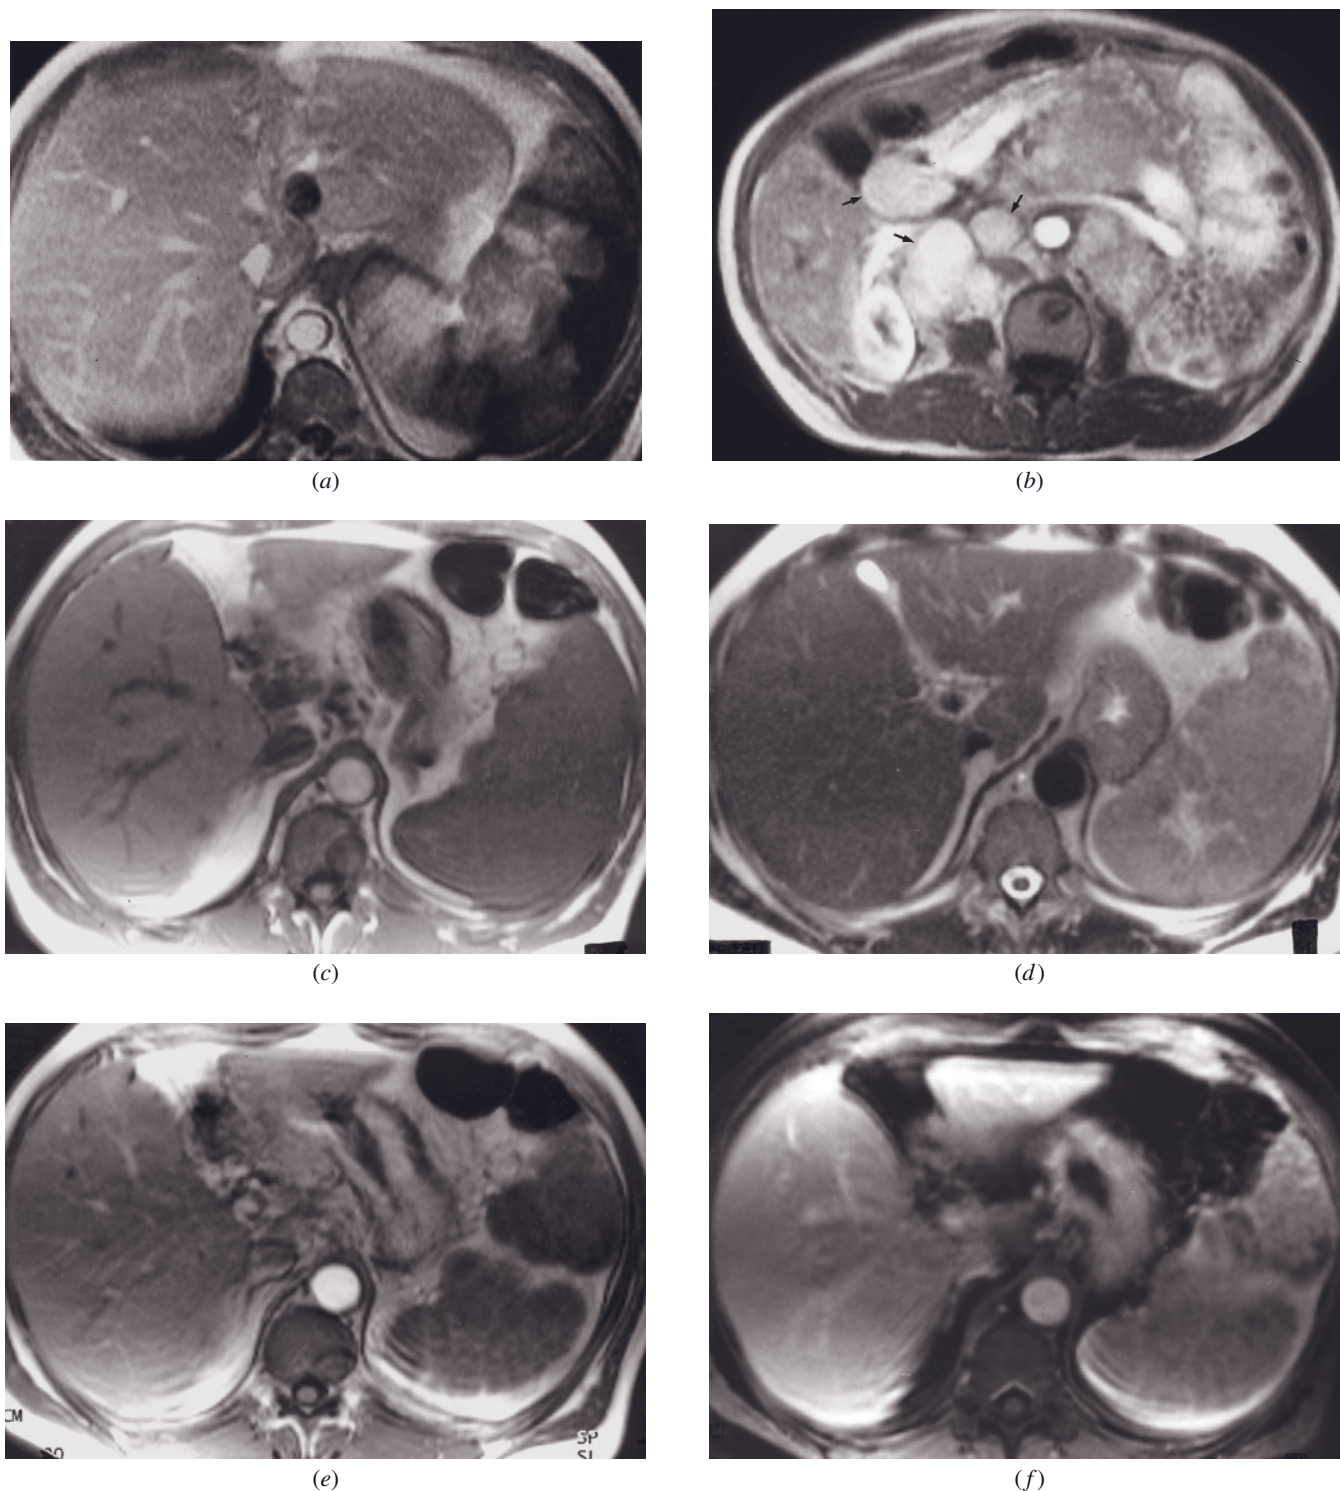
Diffuse infiltration with lymphoma. Immediate postgadolinium T1-weighted SGE image (*a*) demonstrates irregular regions of high and low signal intensity in the spleen in this patient with non-Hodgkin lymphoma. Irregular enhancement is observed in the setting of diffuse infiltration. Immediate postgadolinium SGE image (*b*) in a second patient with non-Hodgkin lymphoma demonstrates irregular enhancement of the spleen consistent with diffuse infiltration. Enhancing lymph nodes (arrows, *b*) are also noted. T1-weighted SGE (*c*), T2-weighted echo-train spin-echo (*d*), immediate postgadolinium T1-weighted SGE (*e*), and 90-s postgadolinium T1-weighted fat-suppressed SGE (*f*) images in a third patient with B cell lymphoma infiltrating the spleen. The spleen is homogeneous in signal intensity on T1 (*c*) and is heterogeneous on the T2-weighted image (*d*). Diffuse heterogeneous enhancement with large irregular foci of decreased enhancement is appreciated on the immediate postgadolinium image (*e*) that persists on the late image (*f*).
